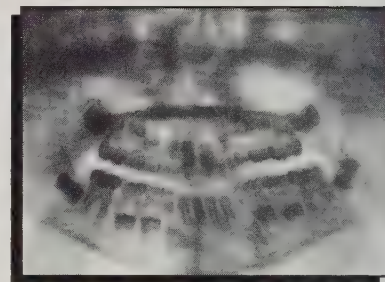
Panoramic radiograph demonstrating the reconstruction of the left temporomandibular joint with a costochondral bone graft.
